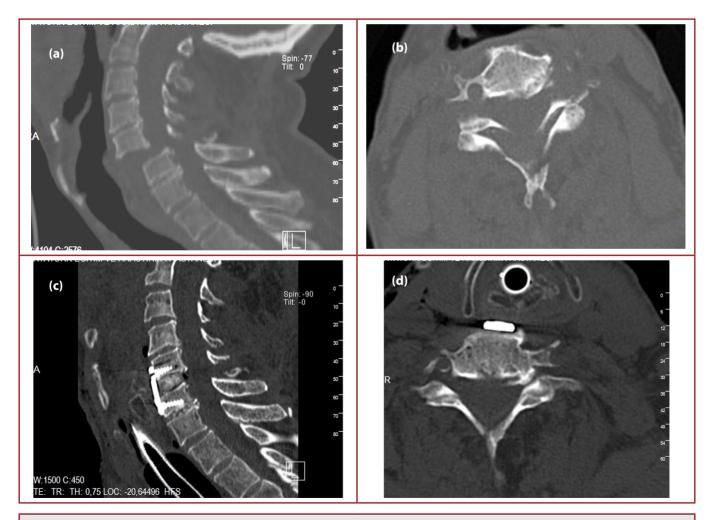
a) Sagital Computed Tomagraphy scan showing C5-6 dislocation. b) Axial Computed Tomography scan showing bilateral locked facet joints at C5-6 level. c) Postoperative sagital Computed Tomography scan. d) Computed Tomography scan showing normal facet joint configuration at C5-6 level.
